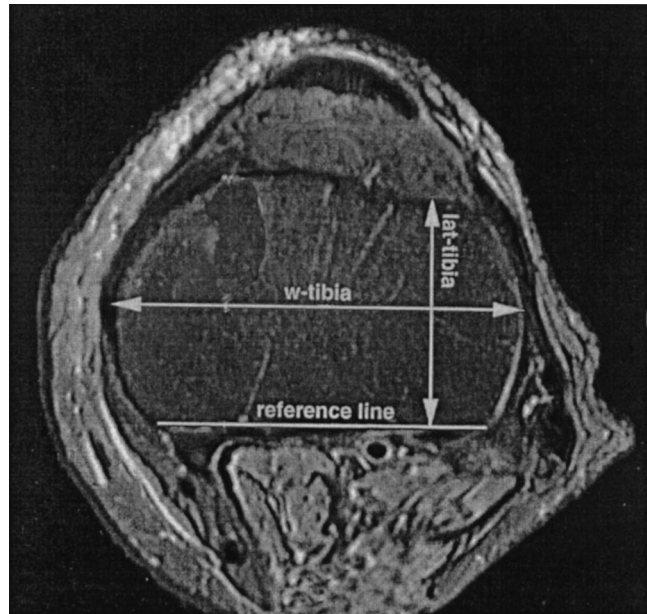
Example MR image of the tibial plateau in the transverse plane indicating two of the four transverse dimensions measured. A reference line was drawn intersecting the most posterior edge of the tibial plateau on the transverse image closest to the joint line. The width of the tibia was measured parallel to the reference line, and the maximum depth of the lateral compartment of the tibial plateau was measured perpendicular to the reference line.
